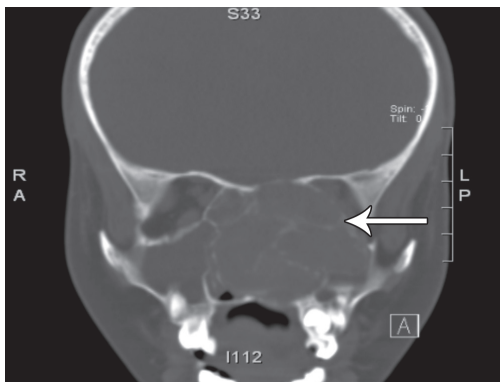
A coronal CT scan showing mass in the nasal cavity.
